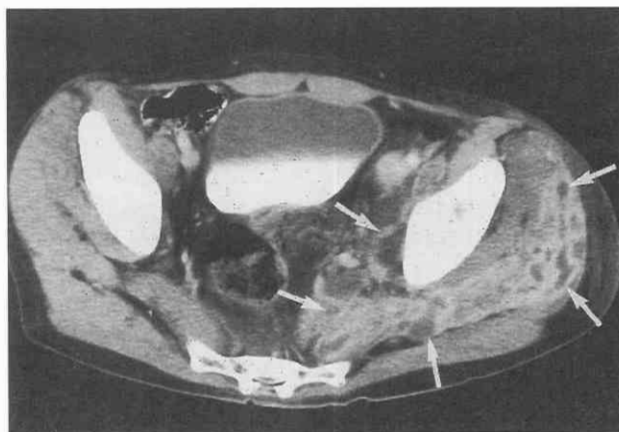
Pyomyositis in a diabetic patient caused by *Streptococcus pyogenes* infection. CT scan shows extensive fluid collections surrounded by intravenous contrast enhancement involving the left obturator internus, piriformis, and gluteus medius muscles (arrows).
